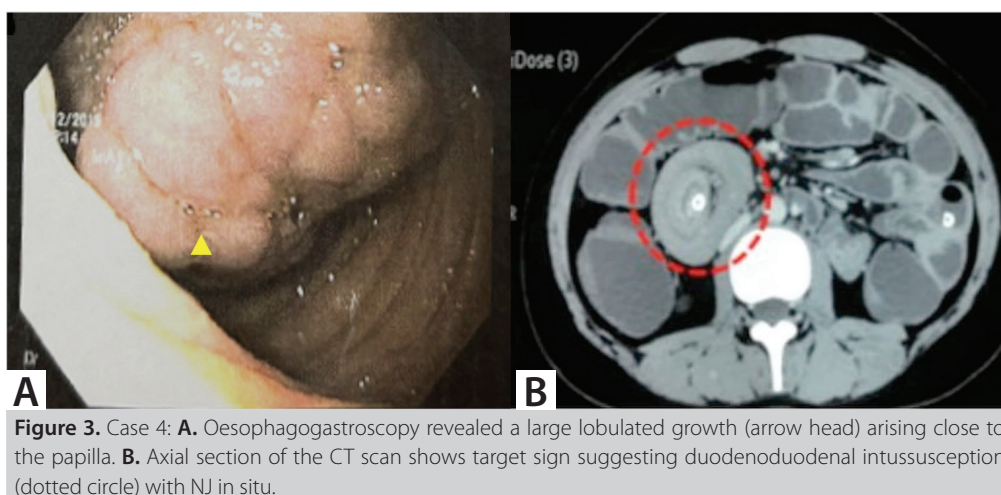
Case 4: A. Oesophagogastroscope revealed a large lobulated growth (arrow head) arising close to the papilla. B. Axial section of the CT scan shows target sign suggesting duodenoduodenal intussusception (dotted circle) with NJ in situ.
